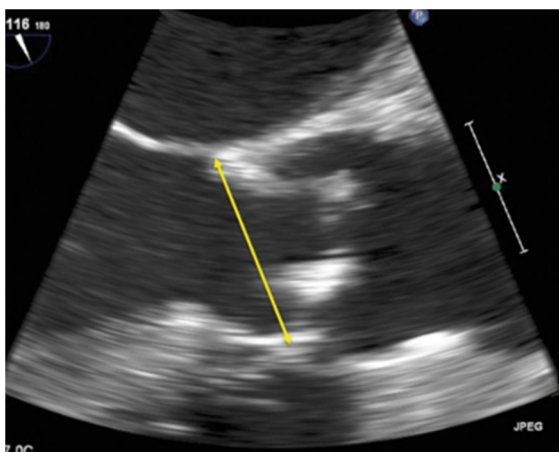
Manual measurement of annulus on Echocardiogram image
